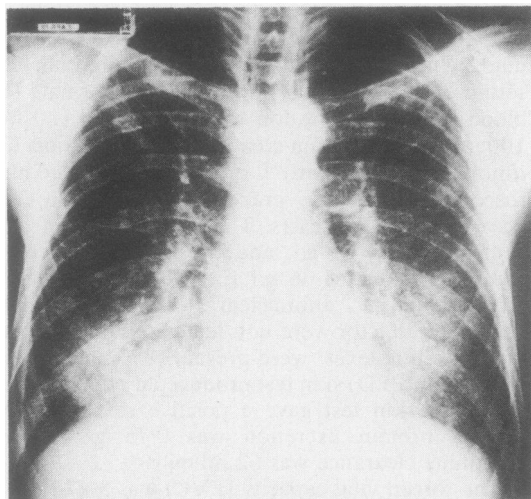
Posterior-anterior chest radiograph taken in April 1979 showing an alveolar filling pattern in both lower lung zones.
